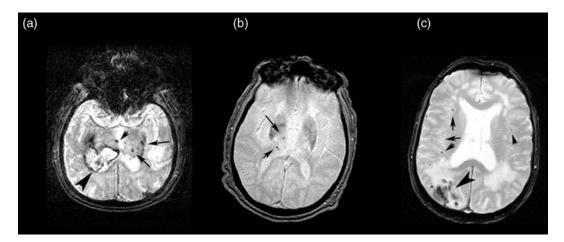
Examples of CMB in different populations. Gradient-echo MRI sequences a in a patient with longstanding history of hypertension with deep intracerebral hemorrhage (*large arrowhead*). This patient also has CMB in contralateral deep structures including the thalamus (*arrows*). b In a patient with CADASIL. Multiple CMB are seen in the thalamus a common location for CMB in CADASIL. c In a patient with probable CAA demonstrating a parietal lobar intracerebral hemorrhage (*large arrowhead*) and numerous CMB in the frontal lobe (*arrows*).
